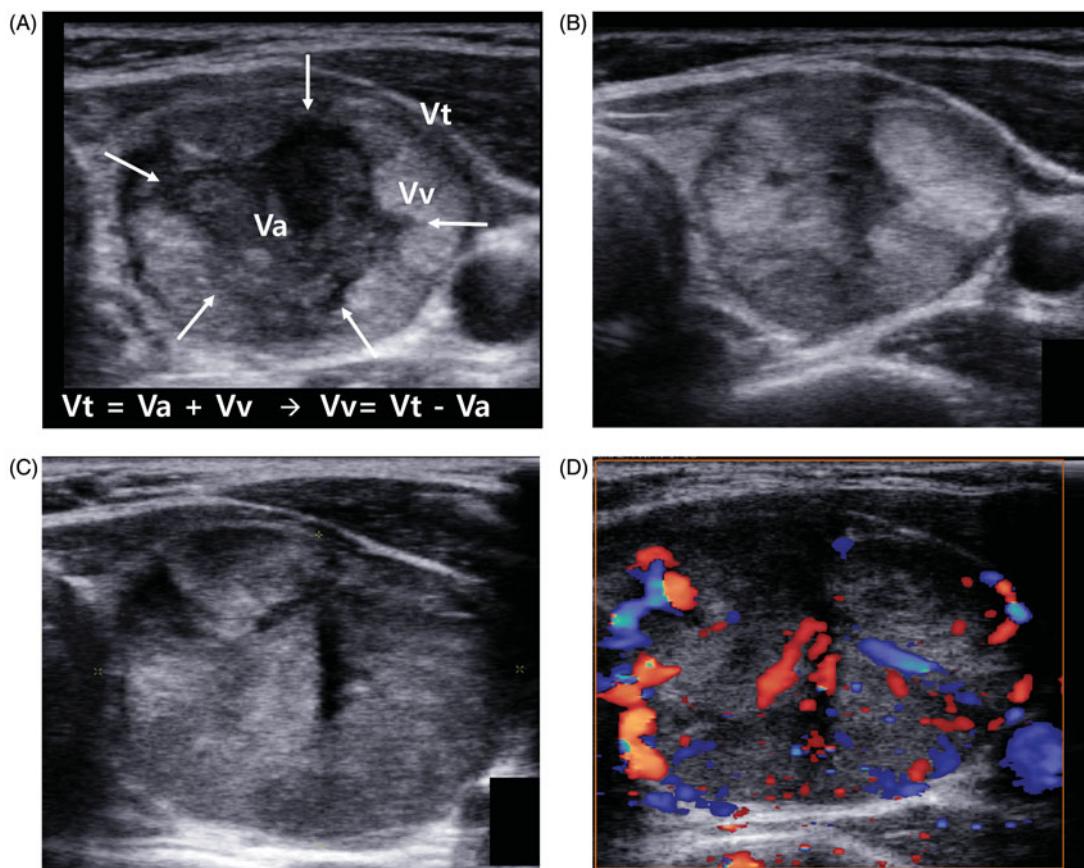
(A) Transverse image from a 29-year-old woman who received RFA for a benign thyroid nodule 4 months previously. The index nodule volume was 21.1 mL. At the centre of the nodule, the ablated area was seen as a hypoechoic area (Va, arrows). At the margin of the nodule, the incompletely treated viable portion showed an isoechoic area (Vv). The volumes at 4 months were $V_t = 7.4$ mL, $V_a = 2.1$ mL and $V_v = 5.3$ mL. (B) Transverse image at the 7-month follow-up. The V_t decreased to 5.3 mL whereas the V_v increased to 5.2 mL. (C) Transverse image at the 21-month follow-up. The V_a decreased and nearly disappeared. The V_t increased to 12.4 mL through an increase in the V_v (12.3 mL). (D) Colour Doppler US image showing increased vascularity in the viable area of the nodule.
